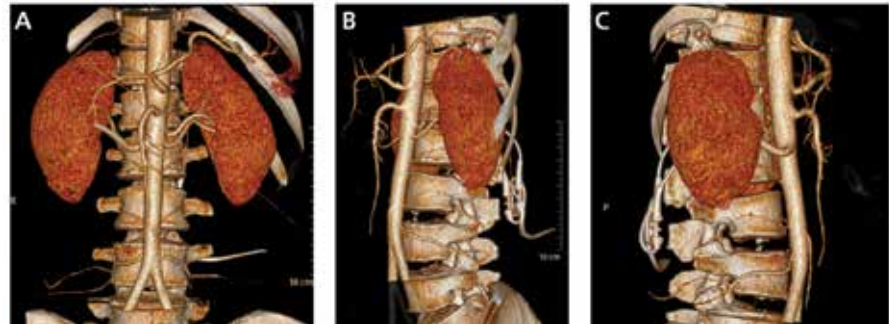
Three-dimensional rendering of computed tomography angiogram revealing no evidence of vascular ischemic/occlusion. (A) anteroposterior view; (B) left lateral view; (C) right lateral view.
